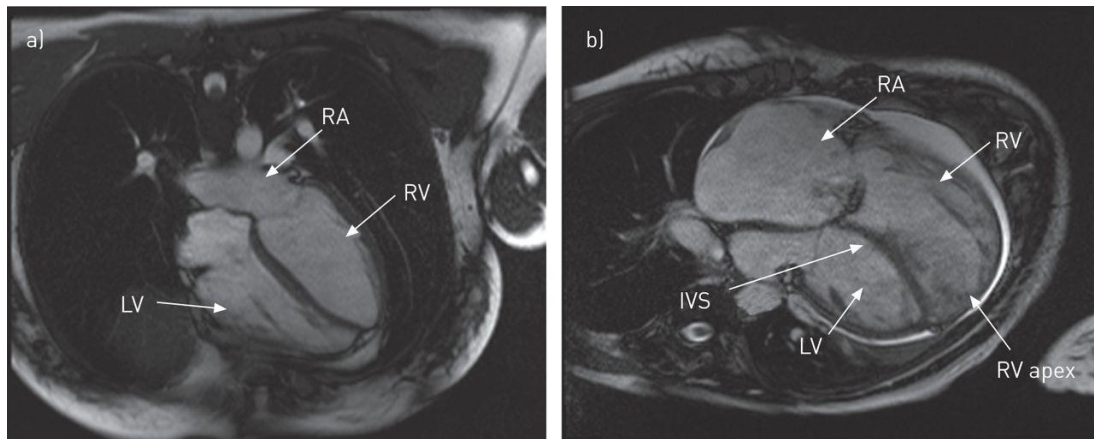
Typical MRI imaging depicting all the four chambers of the heart.
